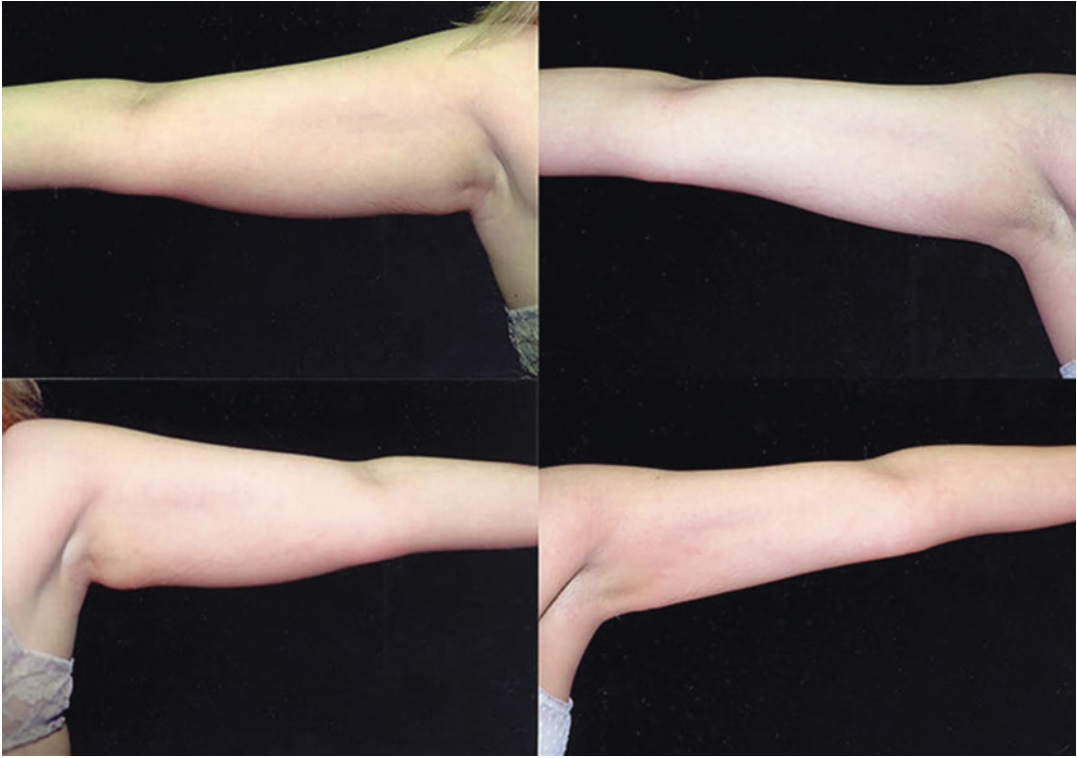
This 34-year-old woman is shown before (*left*) and 3 months after (*right*) ultrasonic liposuction of the arms. Previously she would not wear sleeveless tops. Volumes: right arm, 150 cc; left arm, 175 cc
